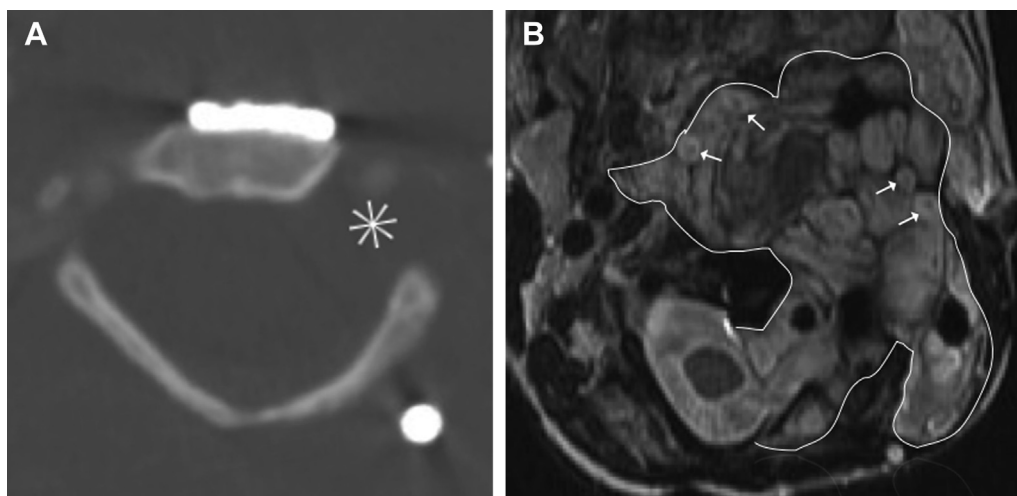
Plexiform neurofibroma in a patient with neurofibromatosis type 1. There is an enlarged left neural foramen (asterisk) on the axial computed tomographic (CT) image (A) related to an expansile mass (outlined) seen best on the corresponding axial T2-weighted magnetic resonance image (MRI) (B). Several target signs (arrows)—a central hypointense region surrounded by homogeneously hyperintense T2 signal—are denoted on MRI. Hardware about the cervical spine is incidentally noted on the CT image.
